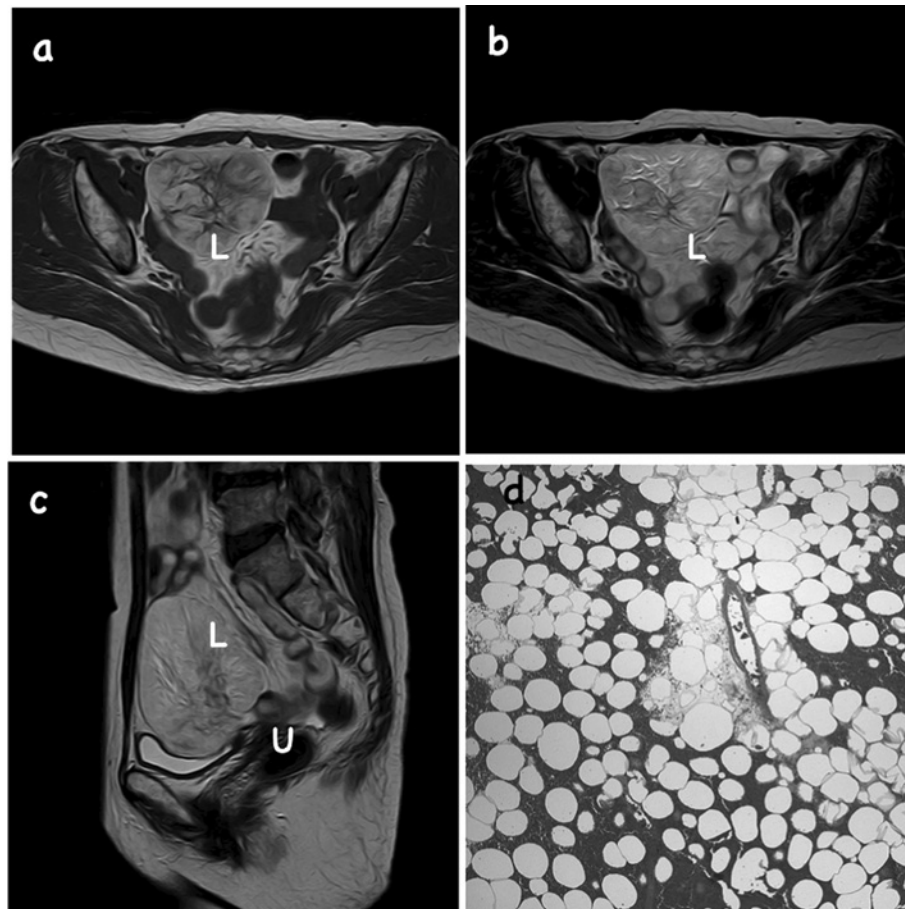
Lipoma of the parietal peritoneum in a 53-year-old postmenopausal female presenting with acute abdominal pain. (a) Axial T1-weighted, (b) T2-weighted and (c) sagittal T2-weighted MR images show a solid mass (L) occupying the pelvic cavity and an atrophic normal-appearing uterus (U). Torsion of an ovarian tumor was suspected due to the slightly higher signal intensity on the T1-weighted image (a), which reflected hemorrhage, and the absence of contrast enhancement. Retrospectively, the identification of normal ovaries may have been hindered by age and menopause. Diagnostic surgery revealed a dark red, twisted (540° rotation) solid mass originating from the parietal peritoneum into the median pelvic cavity. (d) Pathologically, the tumor was diagnosed as a lipoma. The tumor was composed of a well-formed fibrous capsule and mature fat cells. The nuclei of the cells were necrotic due to torsion. MR, magnetic resonance.
